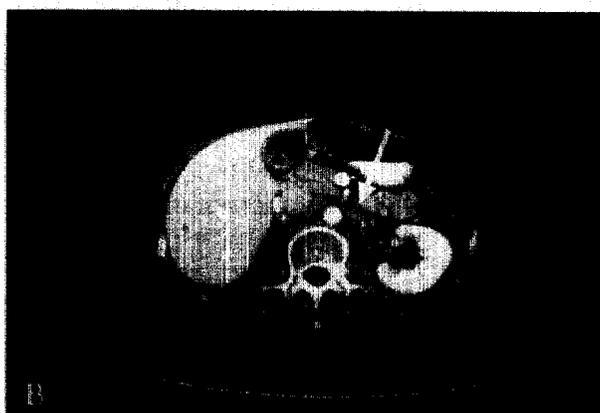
(A) A CT scan of the chest revealed nodular pleural thickening (white arrow) with effusion in the left pleural space. (B) Abdominal CT scan showed para-aortic lymphadenopathy (white arrow).
